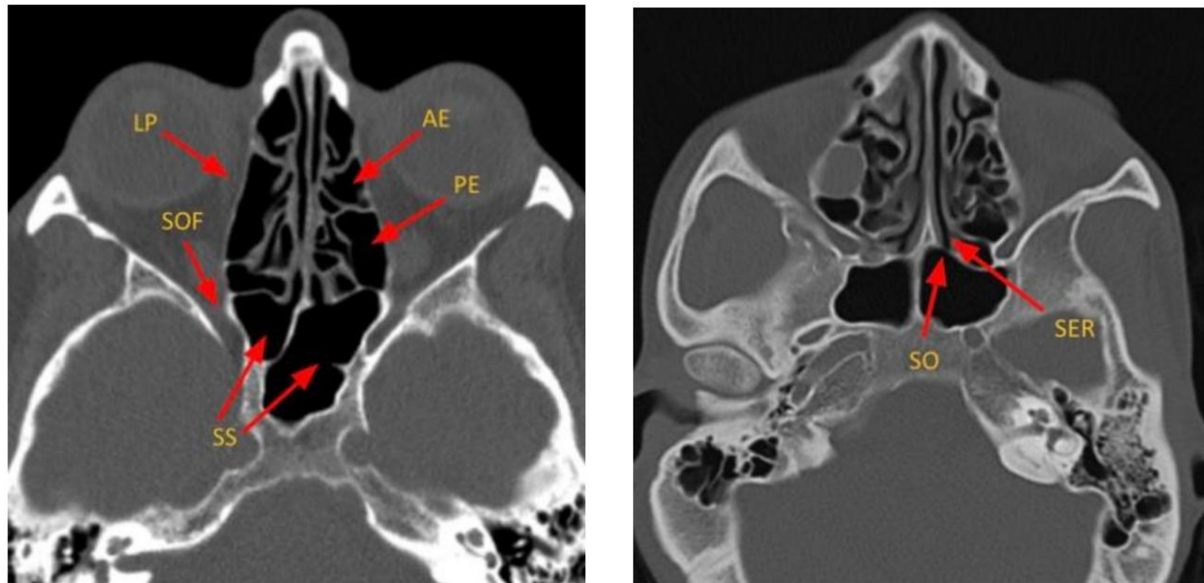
Axial CT images depicting the key components of ethmoid air cells and sphenoid sinuses. LP: Lamina papyracea; SOF: superior orbital fissure; SS: sphenoid sinus; SER: sphenothethmoidal recess; SO: sphenoid ostium; AE: anterior ethmoid air cells; PE: posterior ethmoid air cells; CT: computed tomography.
